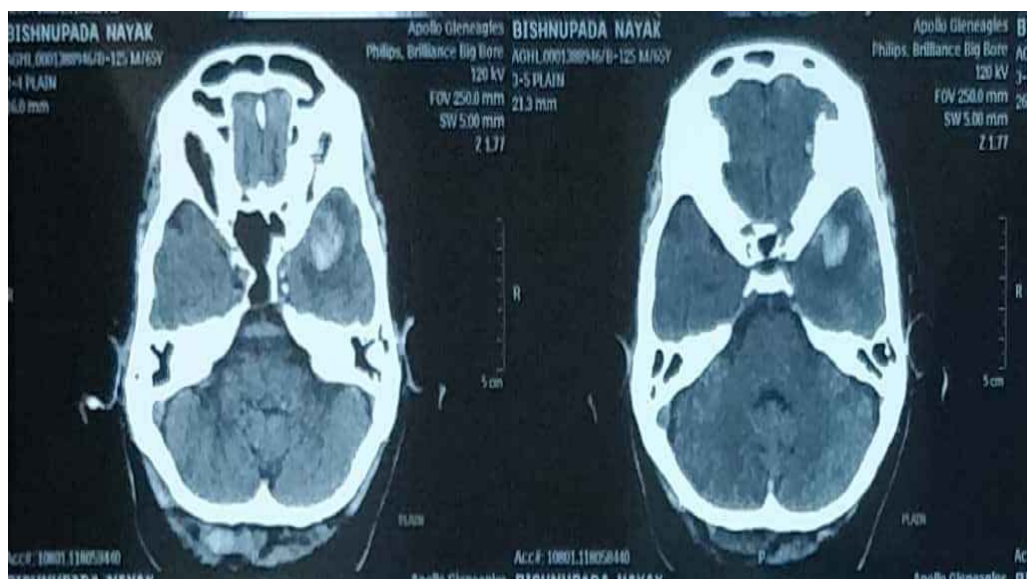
Plain CT Brain showing Hemorrhage in left temporal lobe intracerebral hematoma
